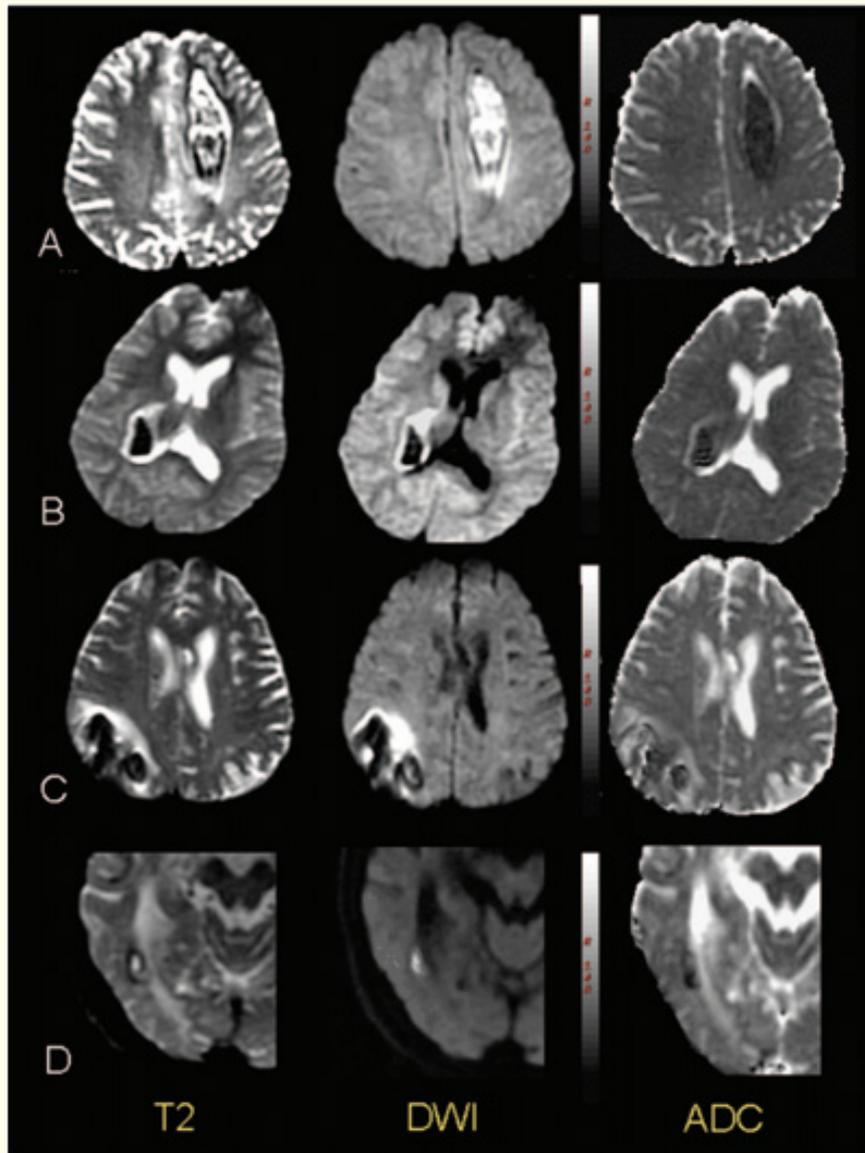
T2 shine-through (A, D) and T2 blackout effects (B, C) in intracerebral hematomas. A, Hyperacute hematoma in a 28-year-old man. The frontal lobe hematoma is isointense on a T1-weighted, hyperintense on a fluid-attenuated inversion recovery (not shown), T2-weighted, and DW image acquired with low ADC values. B, Acute hematoma in a 19-year-old woman. The right capsule-thalamic hematoma is isointense on a T1-weighted (not shown), hypointense on a T2-weighted, and hypointense on a DW image with low ADC values. C, Early subacute hematoma in a 54-year-old man. The right parietal lobe hematoma is hyperintense on a T1-weighted (not shown), hypointense on a T2-weighted, and hypointense on a DW image acquired with low ADC values. D, Late subacute hematoma in a 73-year-old man. The right temporo-occipital hematoma is hyperintense on a T1-weighted (not shown), hyperintense on a T2-weighted, and hyperintense on a DW image acquired with low ADC values. From: Stephane Silvera., et al [9]. There is a persistent black out effect noted in ADC map images.
